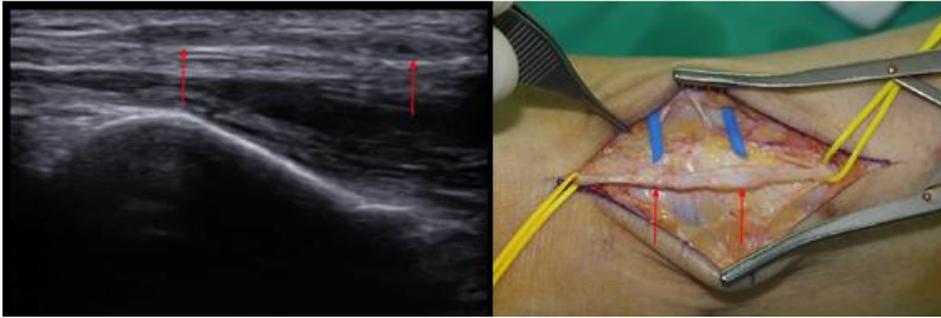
Ultrasonographic findings and intraoperative findings. Two neuromas(arrow) of left superficial peroneal nerve is describe at the ankle level.
